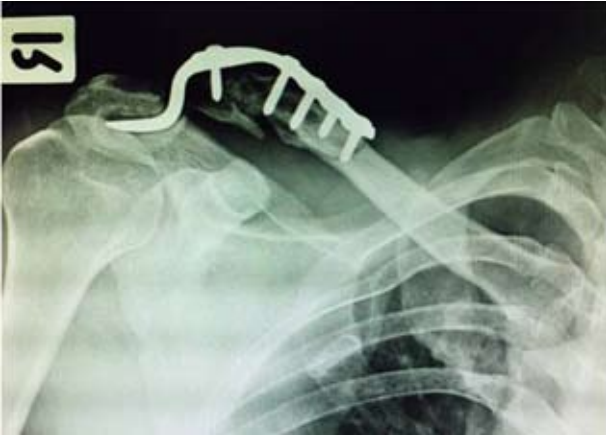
A radiograph showing the clavicle fracture at medial end of the hook plate after the motorcycle accident. Note osteolysis under the acromial surface.
